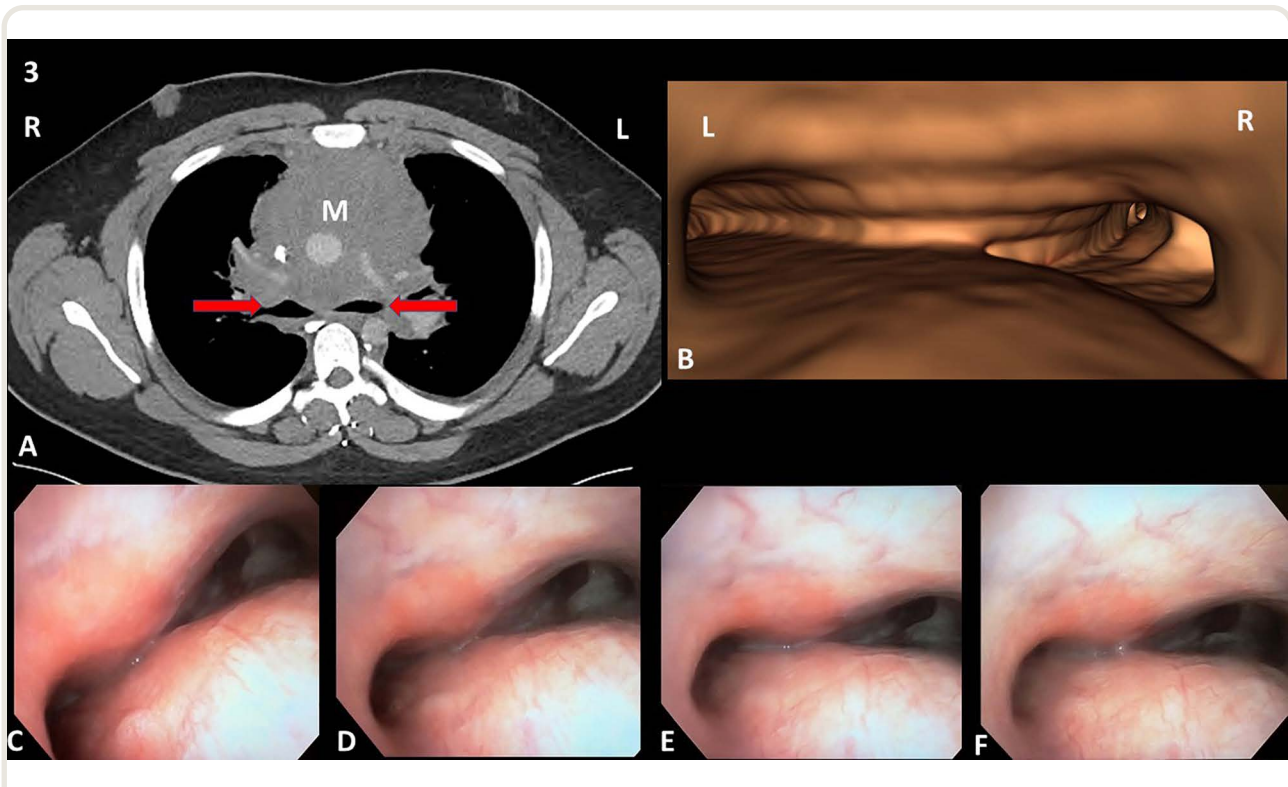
(A) Contrast axial chest computed tomographic scan of subject no. 3 at the level of the carina demonstrating a mediastinal mass primarily anterior to the central airways. *M* indicates the mass. *Red arrows* indicate compressed mainstem bronchi. (B) Digital virtual bronchoscopy of the region of central airway stenosis from the same patient. (C) Actual bronchoscopic still picture of the central airways during baseline awake, spontaneous ventilation; (D) during general anesthesia maintaining spontaneous ventilation; (E) during general anesthesia with positive pressure ventilation; and (F) during general anesthesia with positive pressure ventilation and neuromuscular blockade. See Supplemental Digital Content for all 17 patients' computed tomography scans, virtual bronchoscopies, and still pictures and associated videos demonstrating clinically insignificant changes in airway patency during staged inductions.
